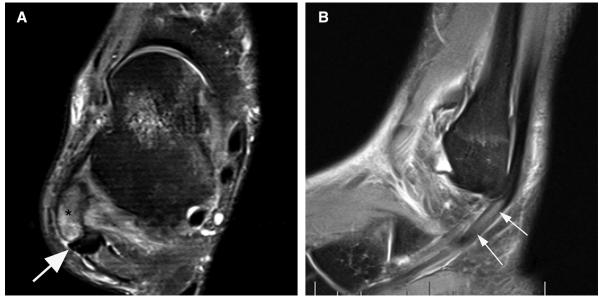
Tendon and retinaculum damage. (A) Axial proton density—weighted turbo spin echo magnetic resonance imaging (MRI) shows the beginning of subluxation of the peroneus brevis tendon laterally due to a grade 1 retinaculum injury with stripping of the superior peroneal retinaculum off the distal fibula (arrow). Note the fibular bone contusion (asterisk). (B) Sagittal proton density—weighted turbo spin echo MRI depicts a longitudinal split tear (arrows) of the peroneus brevis tendon, which was confirmed on T1- weighted axial MRI.
